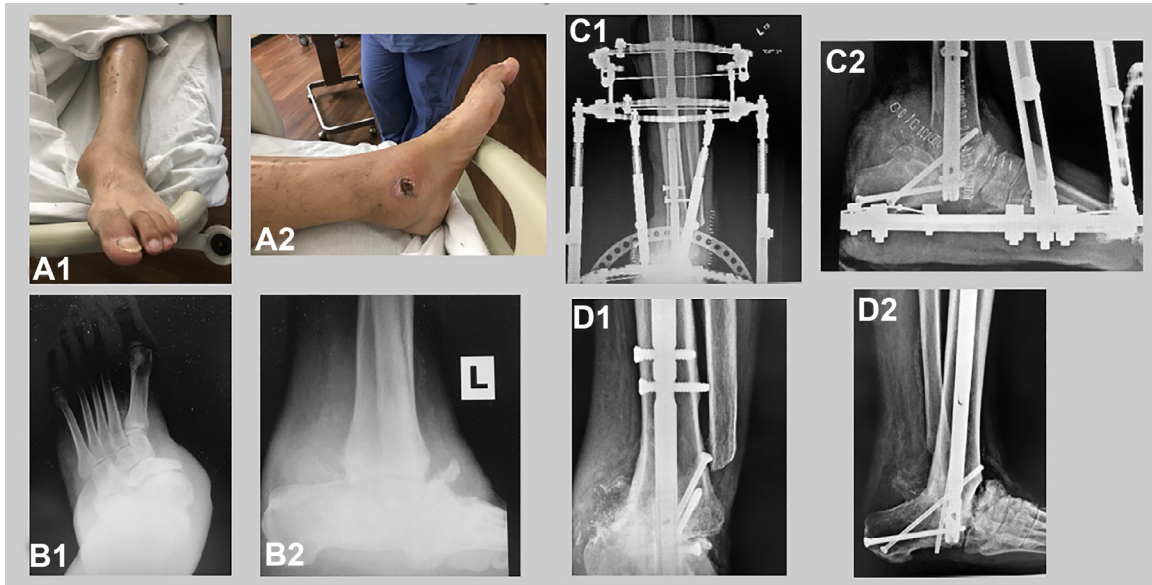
A 47-year-old Hispanic male developed a Charcot deformity in his left ankle that caused a wound of several months' duration along the medial aspect of the ankle. He underwent a talectomy with tibiocalcaneal fusion via intramedullary nail and external fixator with rhPDGF-BB/ β -TCP augmentation. He achieved a successful fusion at 20 weeks. (A1 and A2) Clinical photographs of Charcot deformity with ulceration on foot, (B1 and B2) Preoperative radiographs showing Charcot deformity (AP and lateral views), (C1 and C2) Immediate postoperative radiographs showing talectomy with tibiocalcaneal fusion and placement of intermedullary nail and external fixator with bone graft (AP and lateral views), (D1 and D2) Radiographs showing fusion following removal of external fixator (AP and lateral views).
